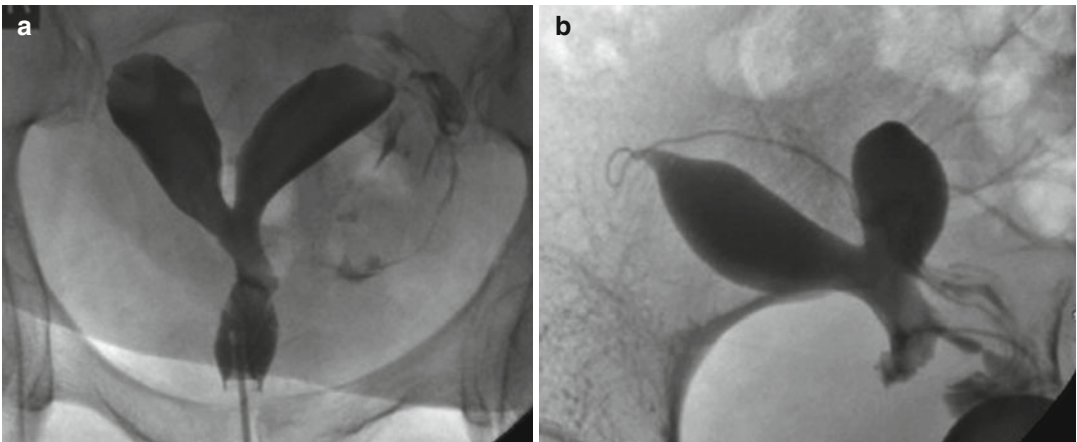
HSG cannot differentiate between a septate and bicorporeal uterine cavity. (a) A 38 year old woman with primary infertility proven on MRI to be a septate cavity
